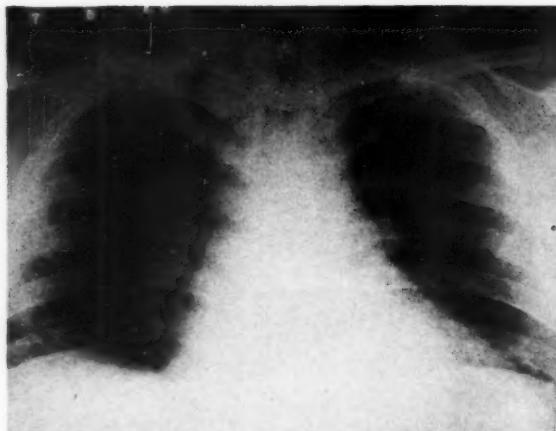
Roentgenogram of the chest showing an unusual density outside the cardiac border that was more radiolucent than the remainder of the cardiac silhouette and extended from the diaphragm to the aortic arch.
